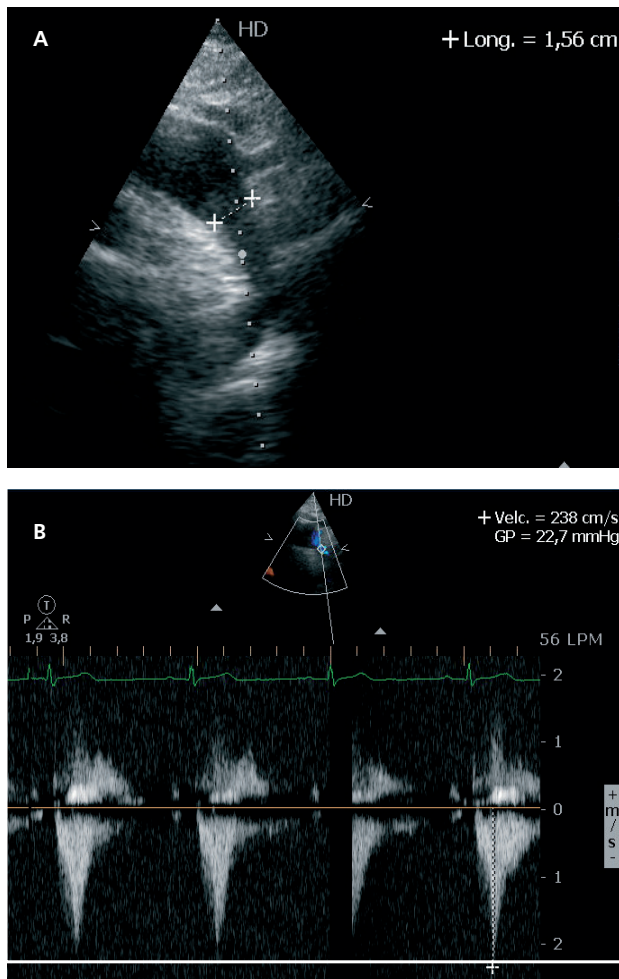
Transthoracic echocardiography. A. Suprasternal view showing the aortic arch and the descending thoracic aorta; an evident change in diameter and narrowing just before the beginning of the descending thoracic aorta (diameter, 15.6 mm) at the level of the supra-aortic trunks are also seen. B. Suprasternal view with continuous Doppler at the beginning of the descending thoracic aorta, showing end-systolic acceleration of flow at that level but with no significant gradient.
